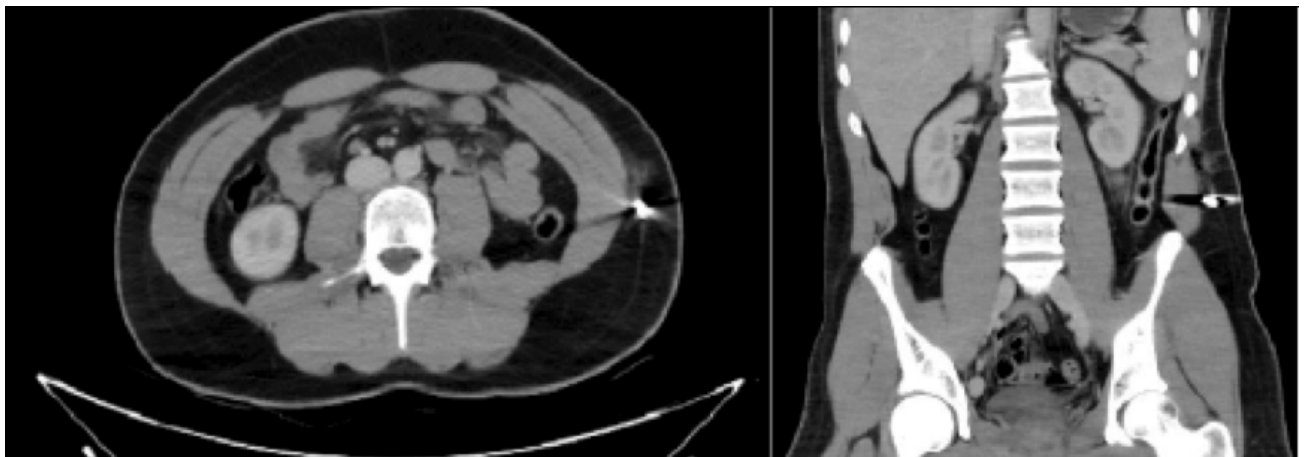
Computed tomography showing a bullet in the left flank without intra-abdominal injury.
